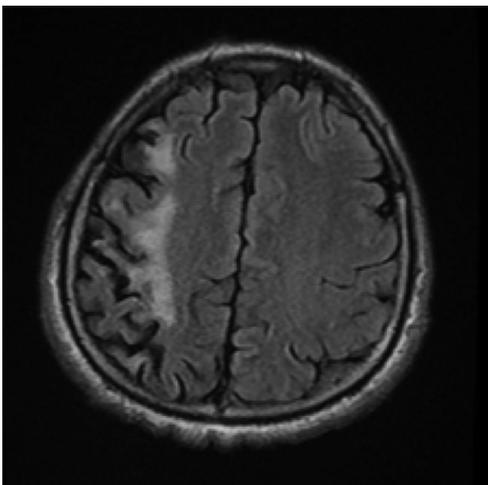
Fluid attenuated inversion recovery (FLAIR) MRI scan shows hyperintense foci in cortico-subcortical region of fronto-parietal white matter.
